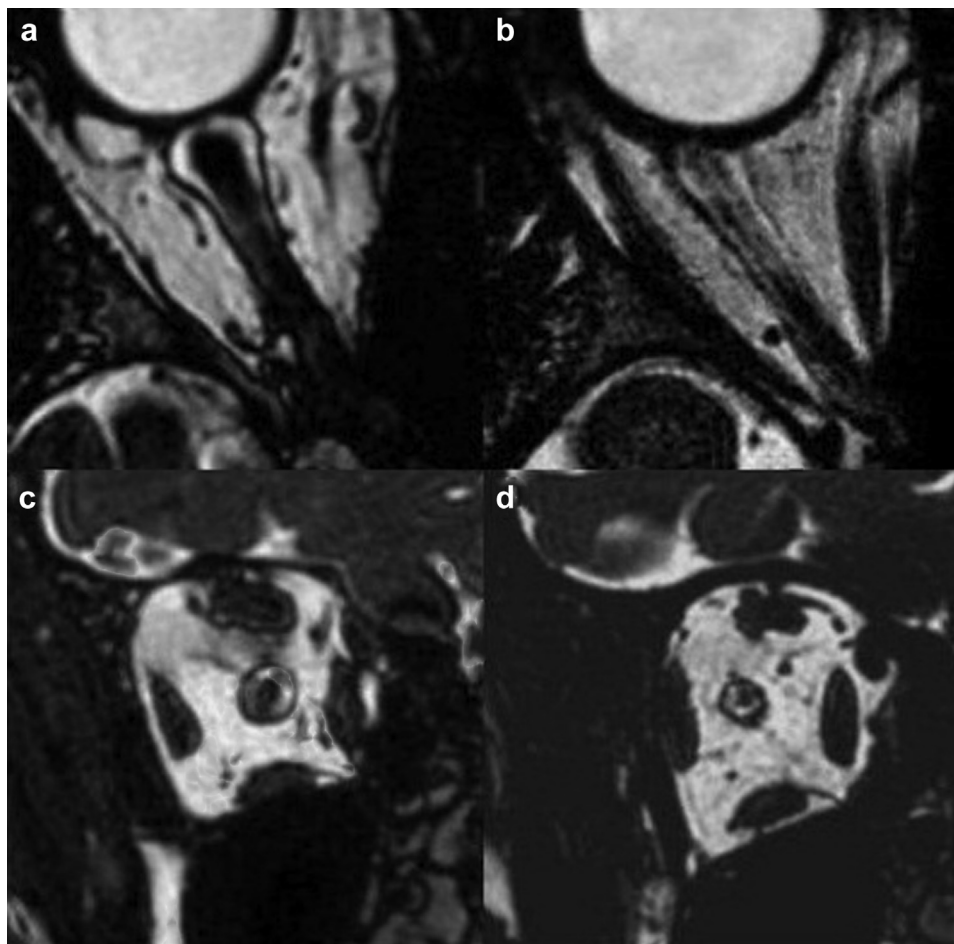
Magnetic resonance images of the optic nerve sheath diameter (ONSD) of a healthy control (a, c) compared with those of a patient with multiple sclerosis (b, d). (a, b) Axial representations. (c, d) Transverse representations. Note the smaller ONSD in the patient with multiple sclerosis, in both the axial and transverse sections. All images refer to T2/T1 bFFE sequences, acquired with SENSE Head 8 channels.
